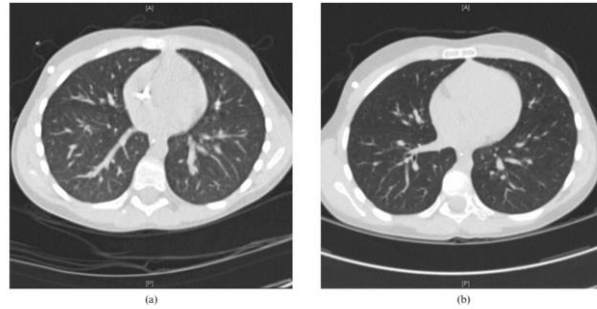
An example of differences in image quality. A 10-year-old girl with Ewing's sarcoma and previous pulmonary metastases underwent unenhanced 2 mm slice thickness spiral (a) 16 multislice CT (16CT) and (b) 64 multislice CT (64CT) examinations within a 3-month period to assess treatment response. Image quality was scored as "3" for the 16CT image and "5" for the 64CT image. The dose-length product was similar (72 mGy cm and 74 mGy cm, respectively) for this particular example.
